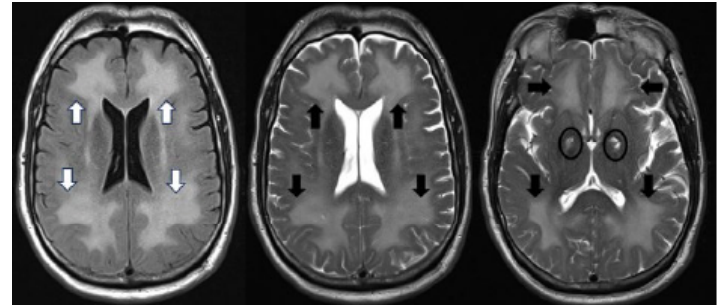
Magnetic resonance imaging 20 days after onset of neuropsychiatric decline (30 days after initial visit) showing marked progression of symmetric hyperintensity in frontal and parietal lobes (axial FLAIR sequence on far left with white arrows, axial T2 sequence in middle and far right with black arrows) and hyperintensity of the bilateral globi pallidi (ovals) with normal-appearing gray matter.
